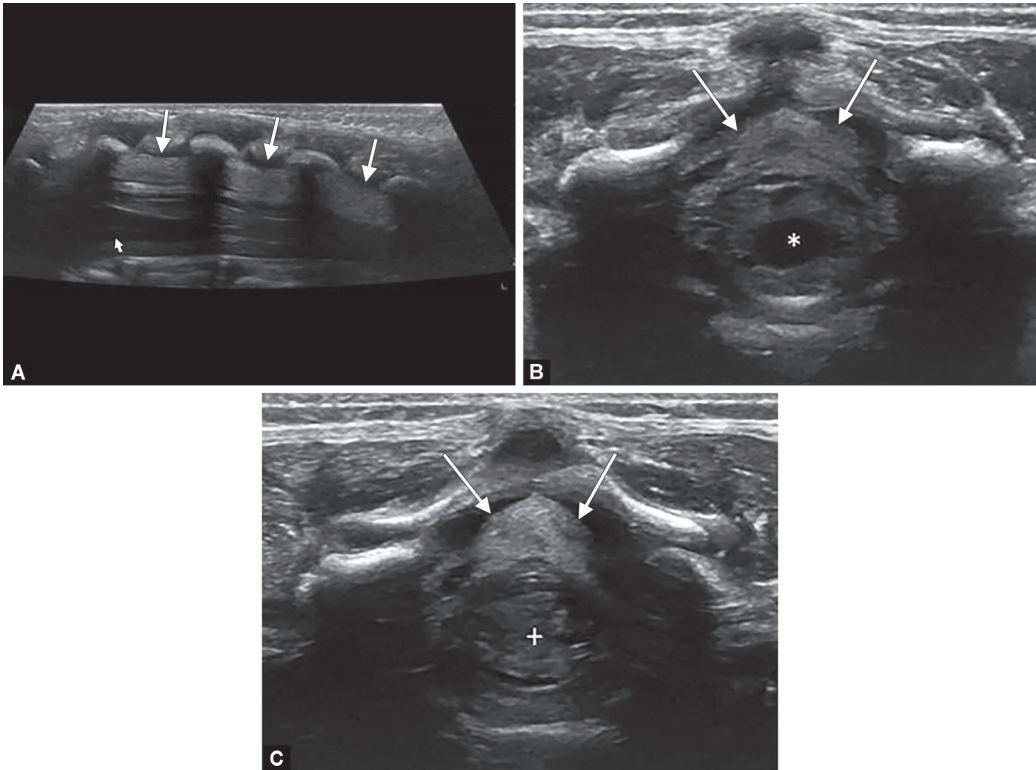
A 6-week-old boy was imaged after lumbar puncture. Sagittal ultrasound (A) of the distal lumbo-sacral spinal cord revealed a homogeneous hyperechogenic tubular epidural hematoma (arrows) displacing the dural sac anteriorly. The tip of the conus medullaris was intact (small arrow). Two axial ultrasound images (B and C) show the dura separating the epidural hematoma from the dural sac (arrows). The spinal cord/conus medullaris (*) and cauda equina nerve roots (+) were seen in the center of the anteriorly displaced dural sac
